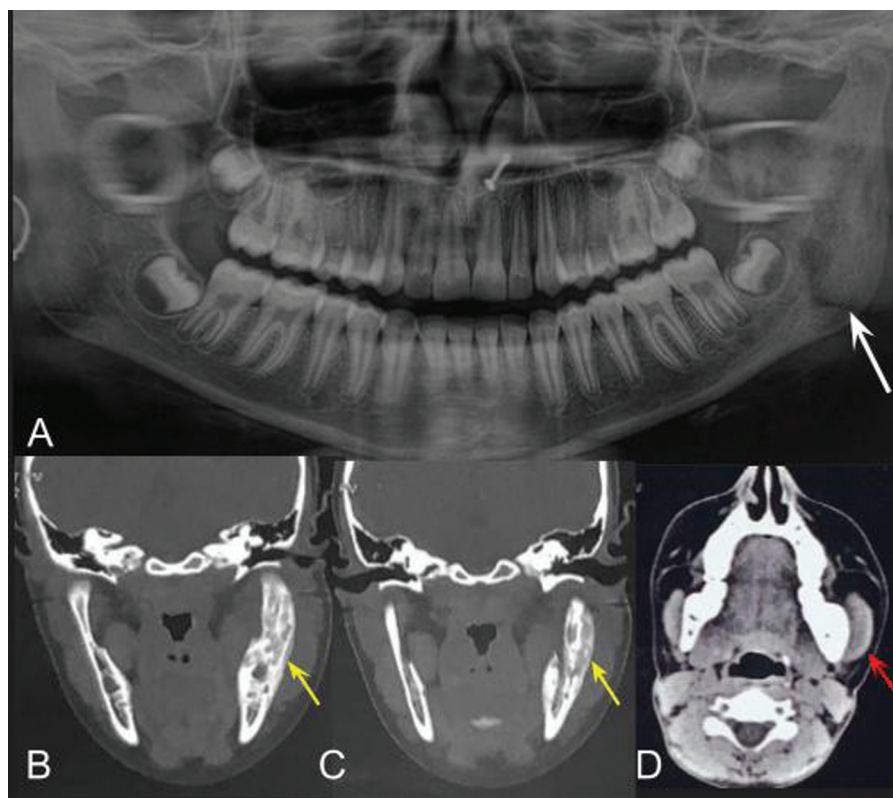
Garre's osteomyelitis. (A) Orthopantomogram (OPG) shows ill-defined sclerosis of left hemimandible predominantly involving the ramus and extending to the posterior body with areas of lysis and cortical perforation (white arrow). Contrast-enhanced computed tomography (CECT) bone window images (B and C) show: bony expansion, cortical thinning, and diffuse sclerosis of the left mandible with focal new bone formation on the buccal side as well as cortical breakthrough surrounding the lesion (yellow arrows). Edema is present within the masseter muscle which appears bulky compared with contralateral side, better seen in soft tissue window (red arrow in D).
